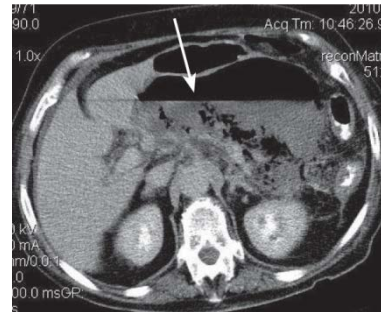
Spiral computed tomography of the abdomen. Abscess of the omental bursa
